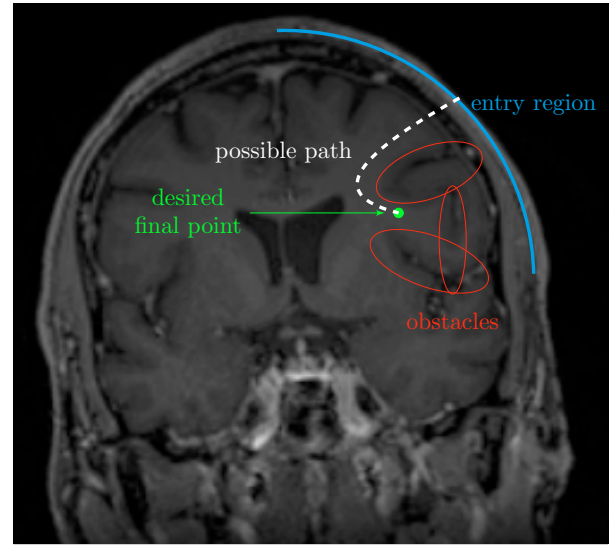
Example MRI footage of a skull. The red ellipses depict outer approximations of sensitive brain areas (here: furrows) and need to be avoided by the cannula. The desired final point (green dot) is located behind the obstacles, such that a stereotactic procedure with straight cannula (within this 2D plane) would cause severe damage. As a remedy, the white dashed line depicts a possible curved trajectory to reach the tumor without crossing the sensitive regions.
